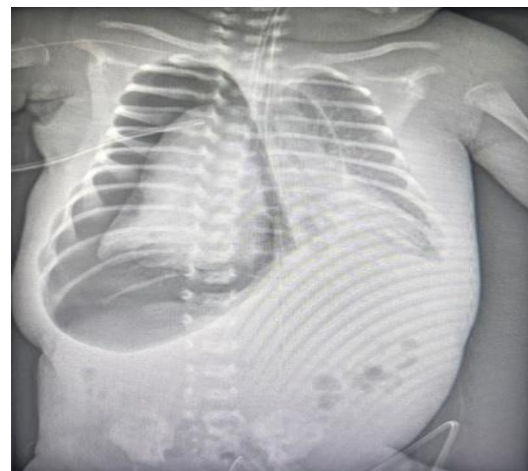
The X-ray image shows the persistent right pneumothorax during the stay.
